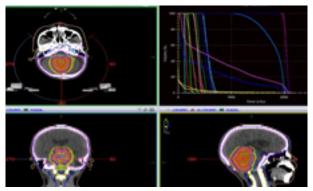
Isodose curve shown on CT images of PTV2
